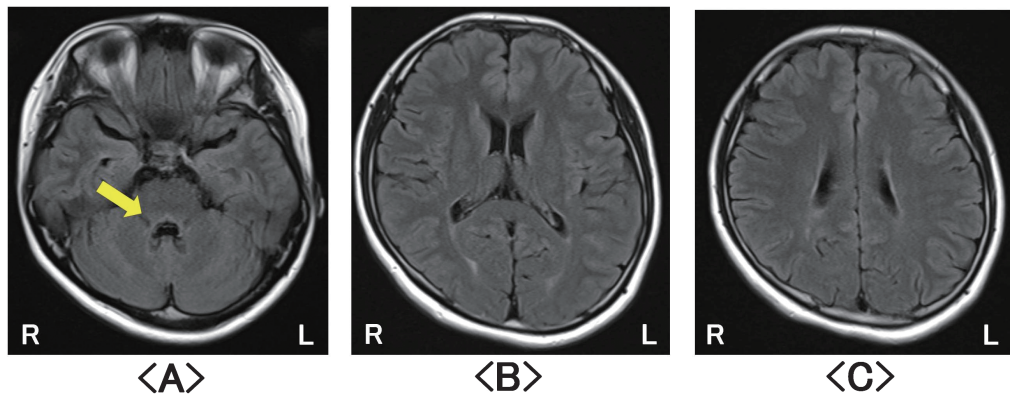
Magnetic resonance images obtained six months later. Fluid-attenuated inversion recovery (FLAIR) showed the improvements in the abnormal signals on FLAIR images, especially in the posterior and medial part of the lower pontine tegmentum (arrow). R, right; L, left.
